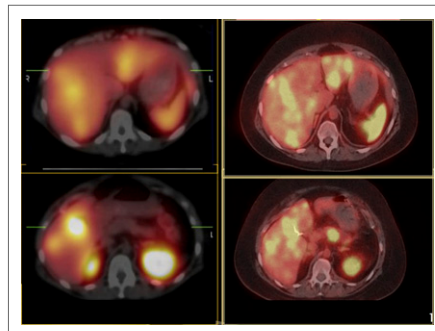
Comparative imaging in patient with neuroendocrine tumors associated with elevated cortisol and adrenocorticotropic hormone, Cushing syndrome, new onset diabetes, liver metastases; otherwise negative ^{111}In -octreotide SPECT (left). ^{68}Ga -DOTATOC PET/CT (right) had higher tumor-to-background ratios and sharper margins, with several lesions not visible on SPECT. An area of intense avidity on the pancreas in the PET/CT image showed no uptake on the SPECT image.
